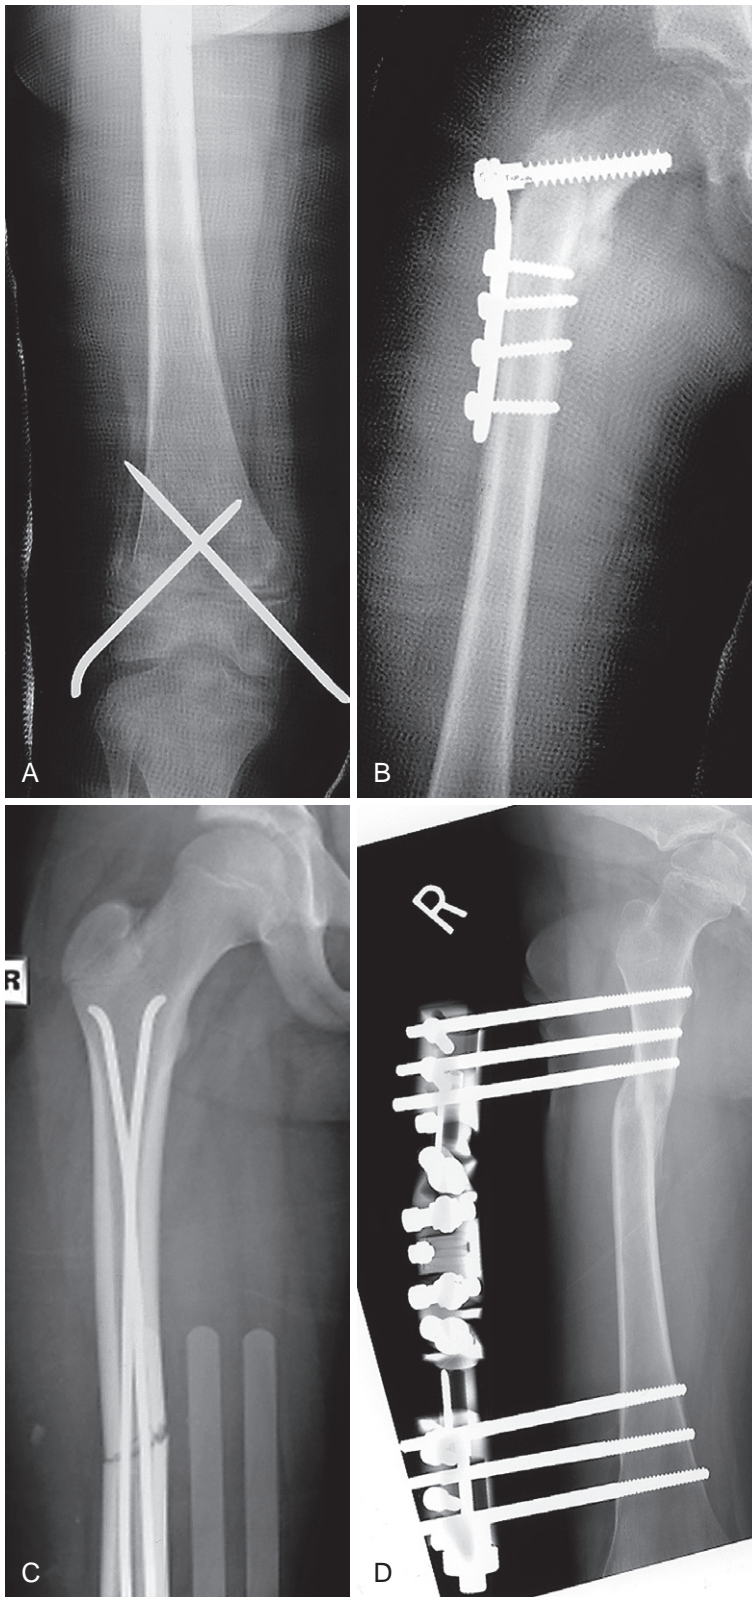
Anteroposterior radiographs of right femur fractures fixed with a variety of fixation methods. A, Salter-Harris type 2 fracture with crossed pins in a 9-year-old girl. B, Intertrochanteric fracture with screws and side plate in a 7-year-old boy. C, Transverse shaft fracture with elastic intramedullary nails in a 13-year-old boy. D, Subtrochanteric fracture with external fixator in an 8-year-old boy.
